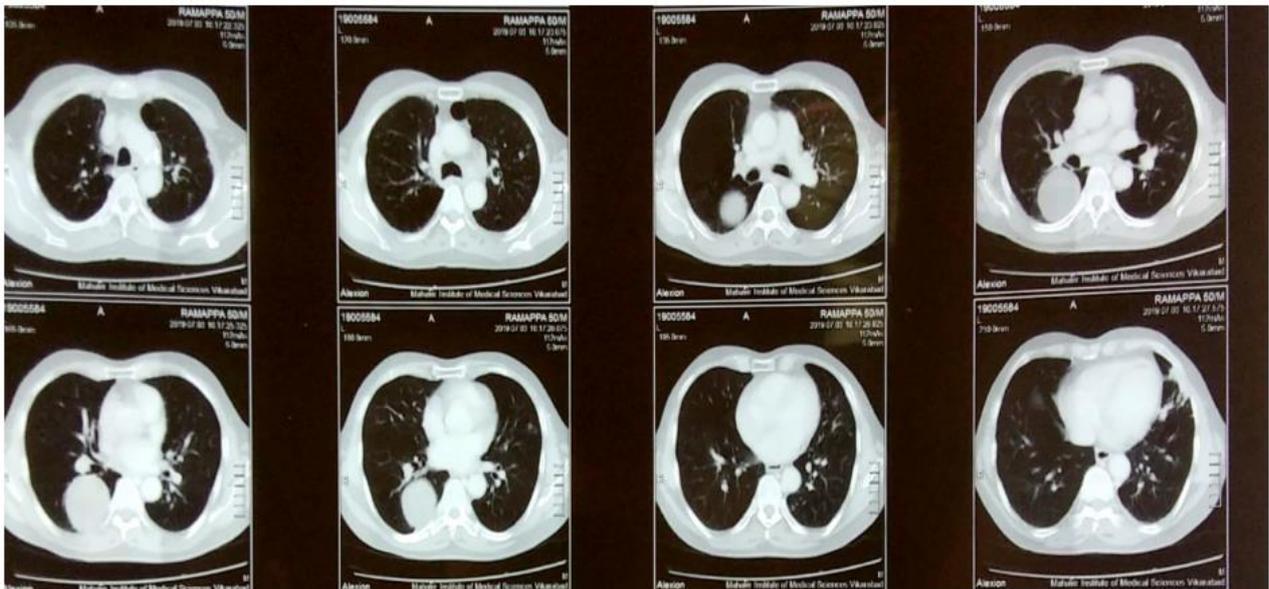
CT scan of chest showed LARGE CYSTIC LESION – 51X54 MM in superior segment of right lower lobe with fluid density without calcification
